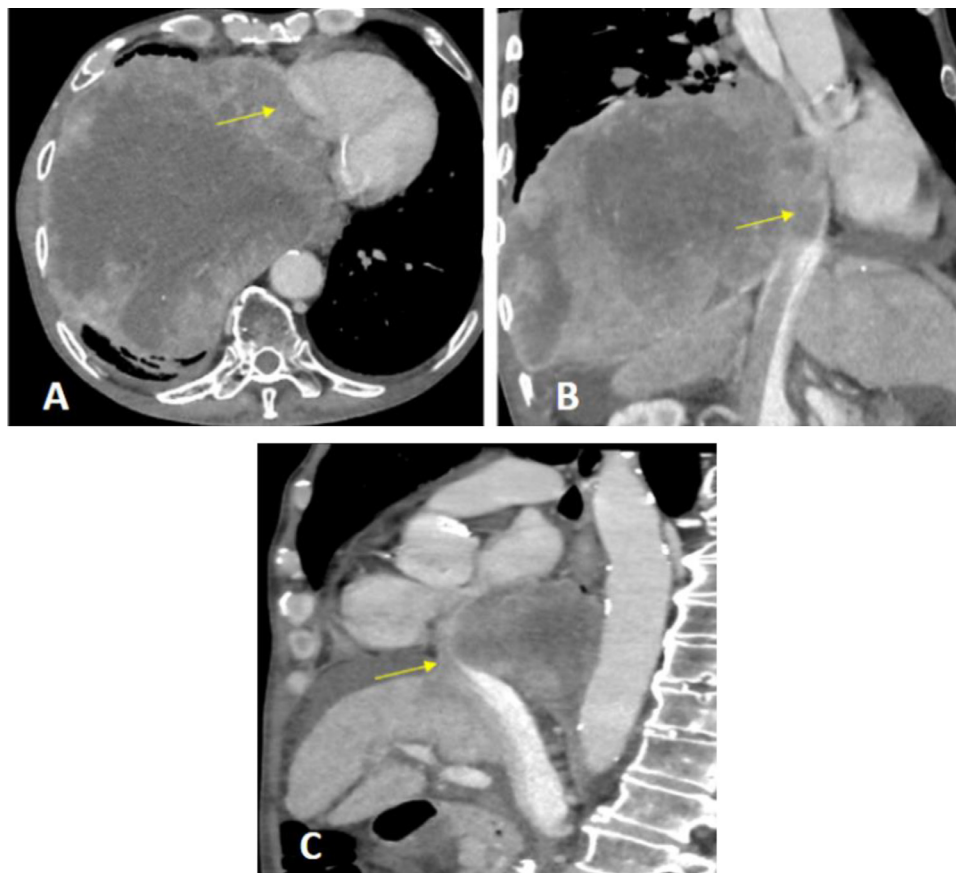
Contrast-enhanced CT reveals a large tumor involving the right lower and middle lung lobe measured (17,6 × 19,3 × 18,6) mm (maximal axial × coronal × sagittal dimension), which causes significant compression of the IVC (yellow arrows) mainly at the level of its entry into the right heart atrium. (A) axial, (B) coronal, and (C) sagittal view.
